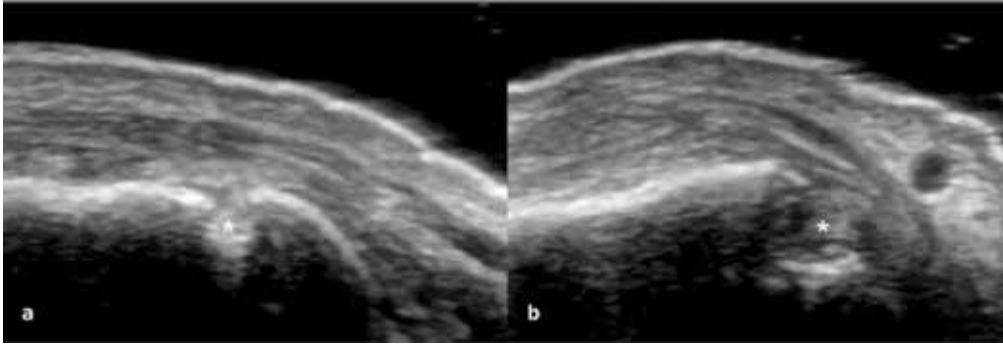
An ultrasound-detected bone erosion (*asterisk*) is discontinuity of the bone surface that is visible in two perpendicular planes at metacarpal head, longitudinal dorsal scan (a) and transverse dorsal scan (b).
